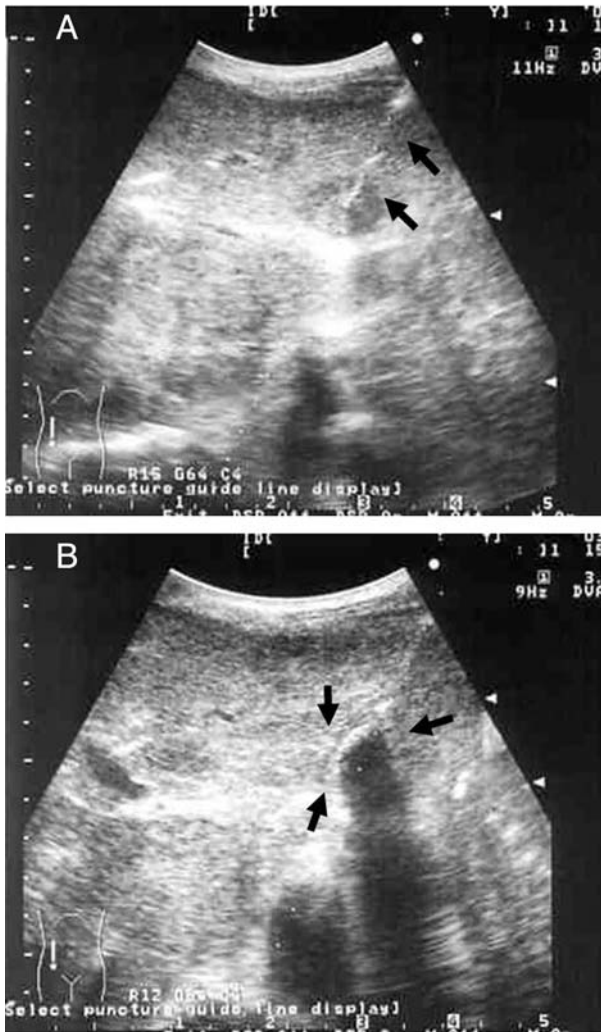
The local effect of percutaneous cryosurgery. The cryosurgery probe (black arrow in A) penetrated the tumor and the size of the ice ball was evaluated (black arrow in B) by intraoperative ultrasound, and freezing was performed for 15 minutes to generate a 3-cm ice ball.
